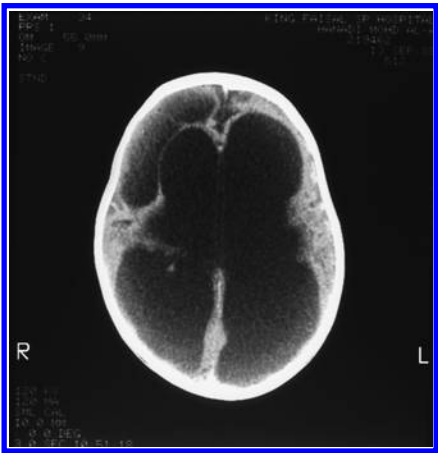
Typical white matter disease with brain filled with water as shown on computed tomography scan.
